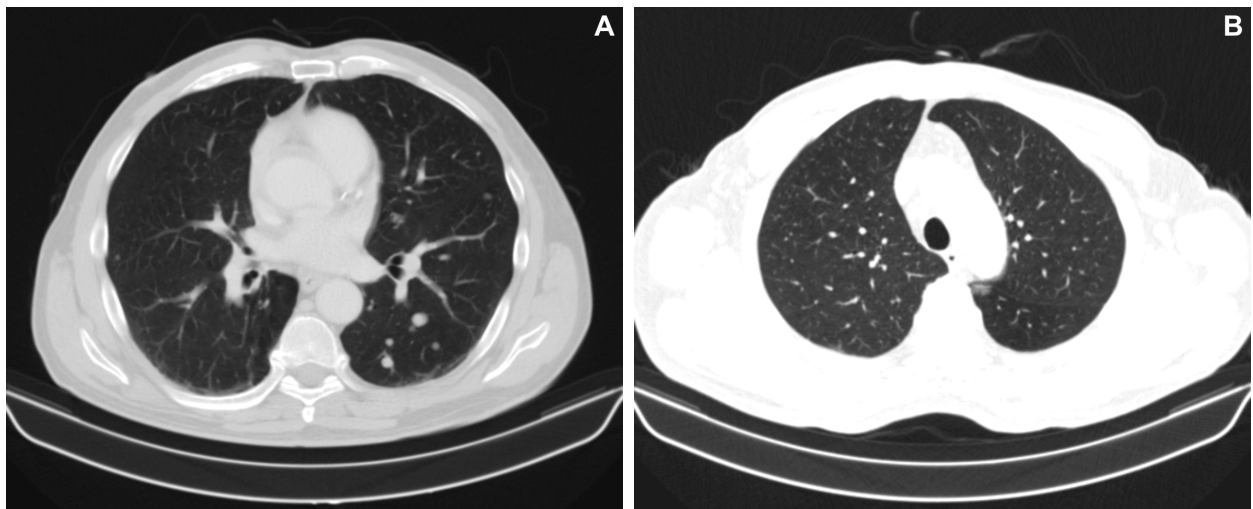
(A and B) Chest CT showing multiple lung nodules and enlarged lymph nodes, suggestive of secondary dissemination.
